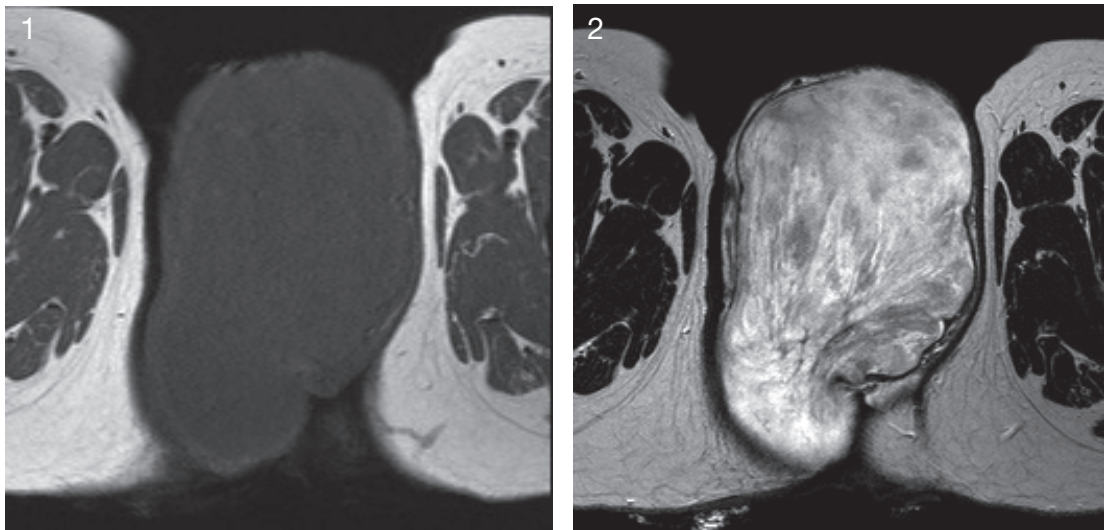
(1) Axial MRI: T1-weighted images showing vulvar mass with isointensity to the muscle.
